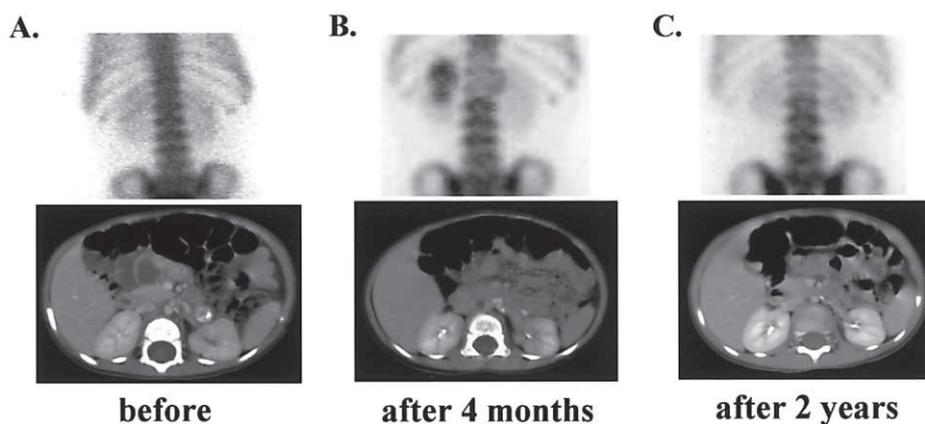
Sequential ^{99m}Tc -HMDP bone scintigraphies and CT scans in Case 2. (A) Bone scintigraphy and CT scan performed 2 months before radiotherapy demonstrate no abnormalities in the kidney. (B) Four months after irradiation, increased accumulation of ^{99m}Tc -HMDP and delayed enhancement of the CT scan were observed in the upper portion of the left kidney. (C) Two years after irradiation, bone scintigraphy showed accumulation defect at the upper pole of the left kidney. CT scan showed atrophy of the medial part of the left kidney.
